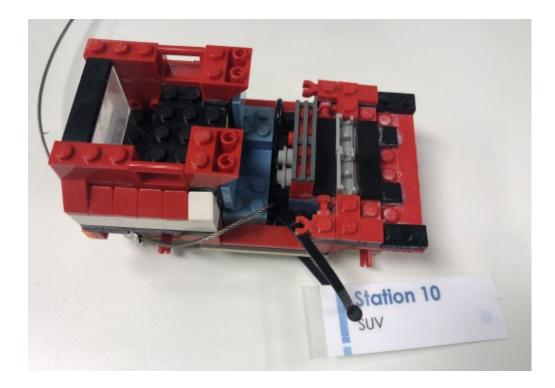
Station 10 SUV Check Piece
